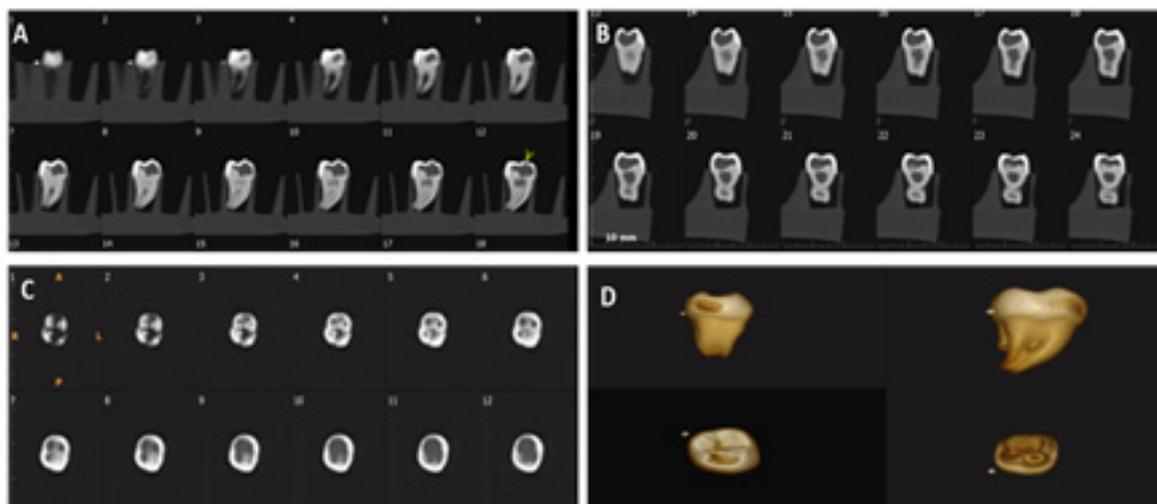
Cone beam computed tomography, no external cavity, note the enamel integrity. A: Sagittal cuts. B: Coronal cuts. C: Axial cuts. D: 3D images.
